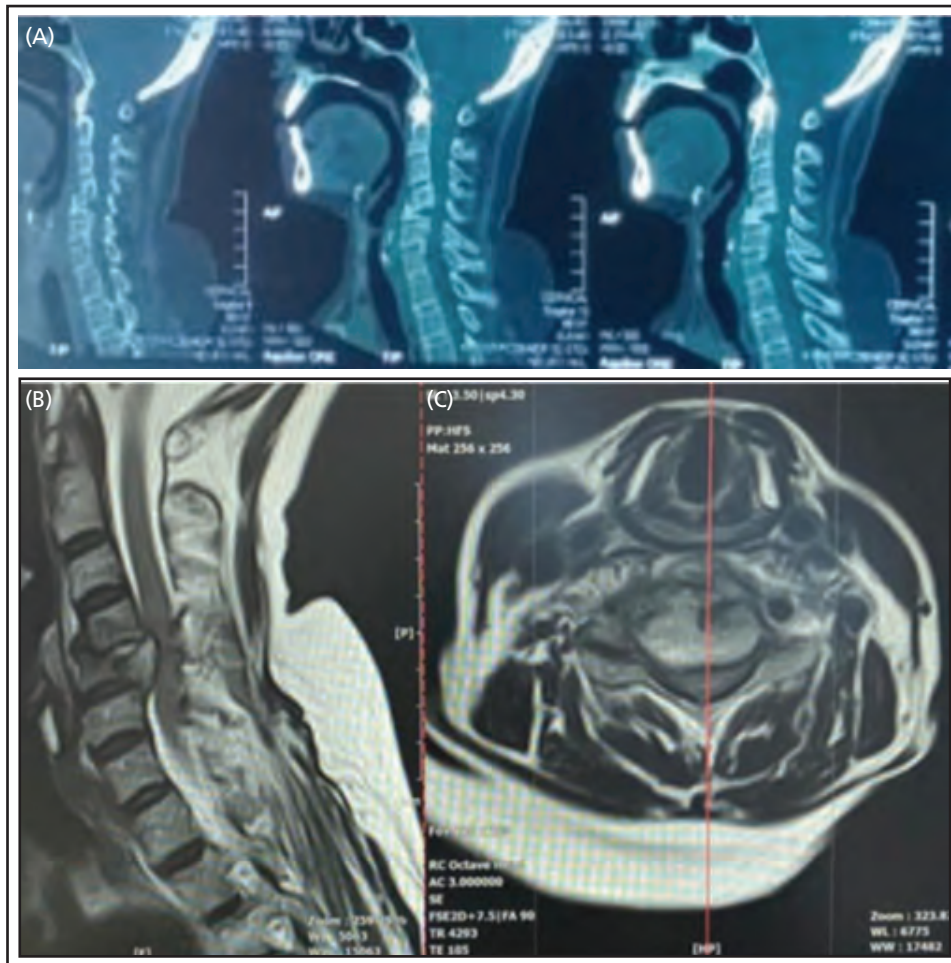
Preoperative CT cervical (A) and MRI cervical (B, C) showing signal changes and pathological fracture of C5 vertebral body causing spinal cord compression
